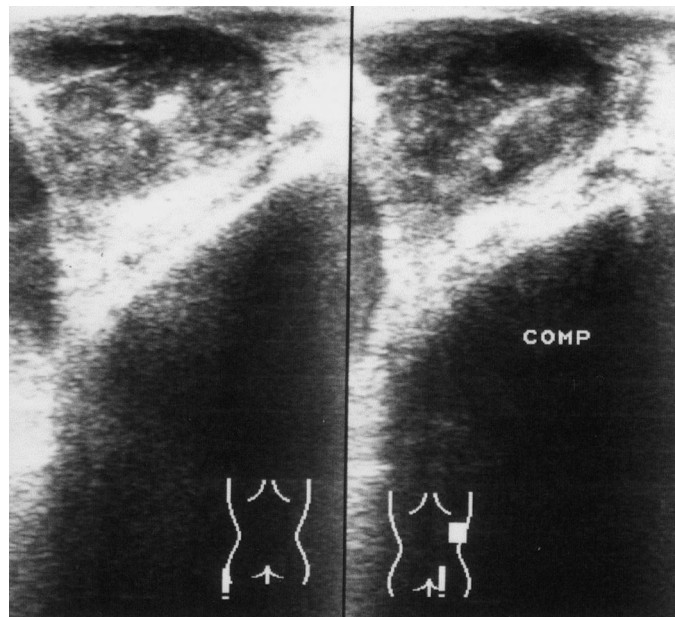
Transrectal ultrasound with linear array probe reveals small hypoechoic subcapsular prostate lesion in periphery of prostate (left). Lesion retained original shape when pressure was applied with probe (right). This nondeformability was considered indicative of probable malignancy.
